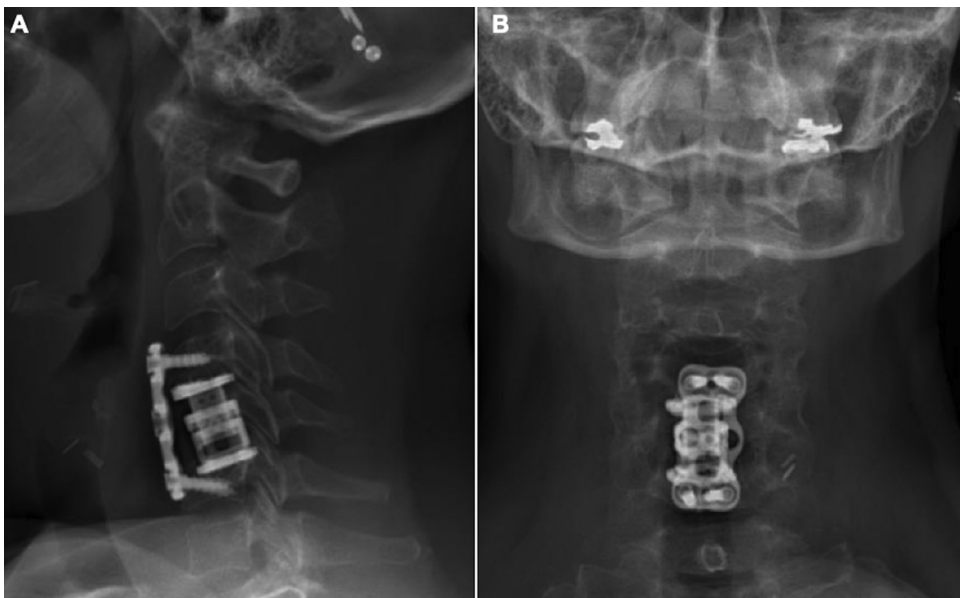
Panel A shows the lateral and Panel B shows the AP 8-week postoperative radiographs showing posterior migration of the interbody cage along with compression of the C6 superior endplate.
